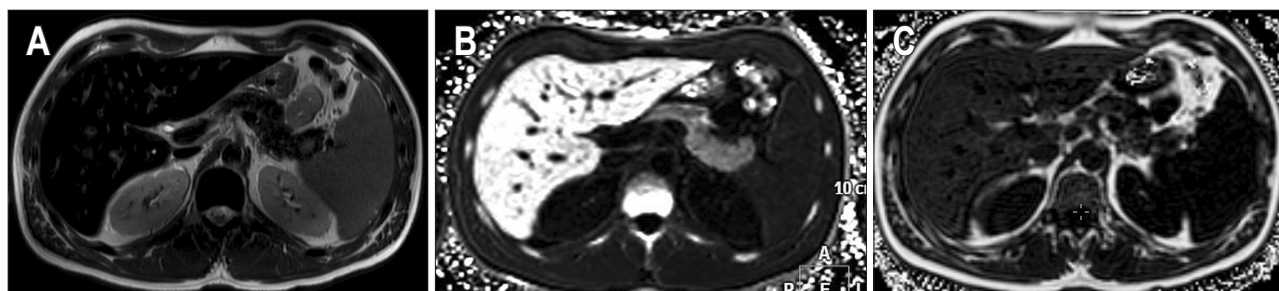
Chemical shift encoded magnetic resonance images of a patient with hereditary hemochromatosis and severe iron overload in the liver and pancreas. T2-weighted (A), $R2^*$ map (B) and proton density fat fraction (PDFFF) maps (C) are shown. There is low signal intensity of the liver and pancreas on T2 images due to iron deposition and normal signal intensity of the spleen. On the $R2^*$ map, the liver and pancreatic $R2^*$ are elevated (435 s^{-1} and 190 s^{-1} , respectively) and the spleen $R2^*$ is normal (50 s^{-1}). Mild hepatic steatosis was also observed on PDFFF images (~9%).
